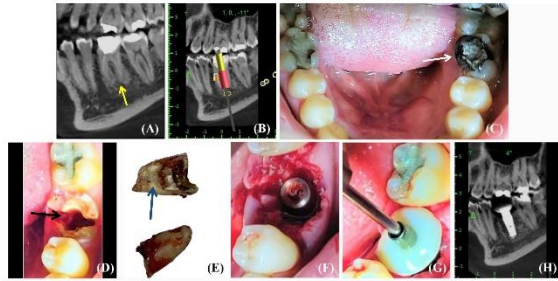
Root-guided technique in immediately placed implant. (A), Pre-operative CBCT x-ray showing badly destroyed mandibular left first molar (yellow arrow). (B), CBCT x-ray showing the virtual planned implant. (C), a pre-operative clinical photograph with severely damaged left mandibular first molar (white arrow). (D), a photograph showing the drilling site between the roots before extraction (black arrow). (E), a photograph of the extracted roots with drilling trace (blue arrow). (F), a photograph of the implant insertion. (G), A photograph of the customized healing abutment. (H), a post-operative CBCT x-ray showing implant placed in the inter-radicular bone like the treatment plan in (B).
